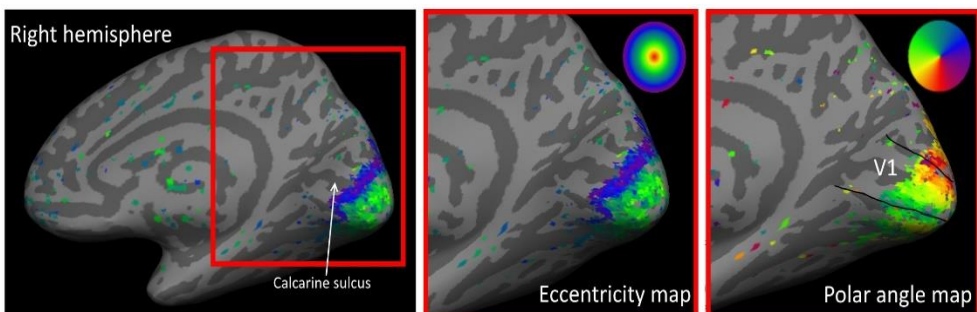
Functional magnetic resonance images of the visual cortex. Eccentricity map shows in same color the activation that is caused by stimuli that are presented at the same distance away from the fovea. There were no stimuli presented to the fovea in the sequence; therefore, the foveal activation is missing from the figure. Polar angle map shows the angle from the fovea at which the stimulus was presented.
